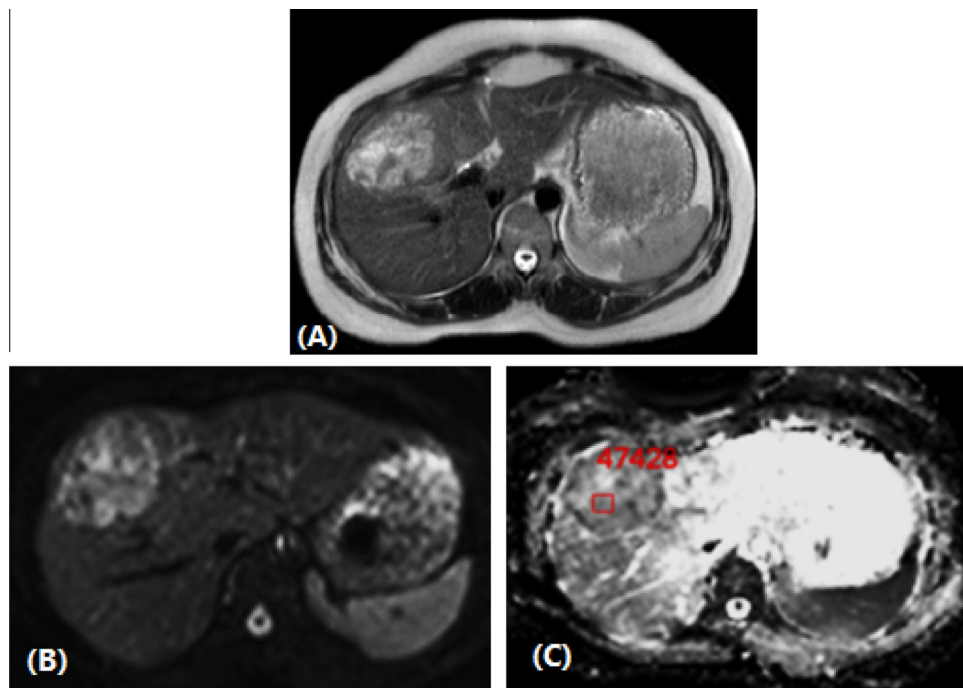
Liver hemangioma in a 38 year-old female patient. (A) Axial T2-weighted image discloses a lobulated hyperintense lesion in the right lobe. (B) Axial single-shot echo-planar DW image ($b = 600$), the hemangioma persists with high signal intensity (tissue with greater cellularity/T2 shine-through). (C) The ADC map shows the lesion is isointense with a high ADC value ($3.8 \times 10^{-3} \text{mm}^2/\text{s}$).
